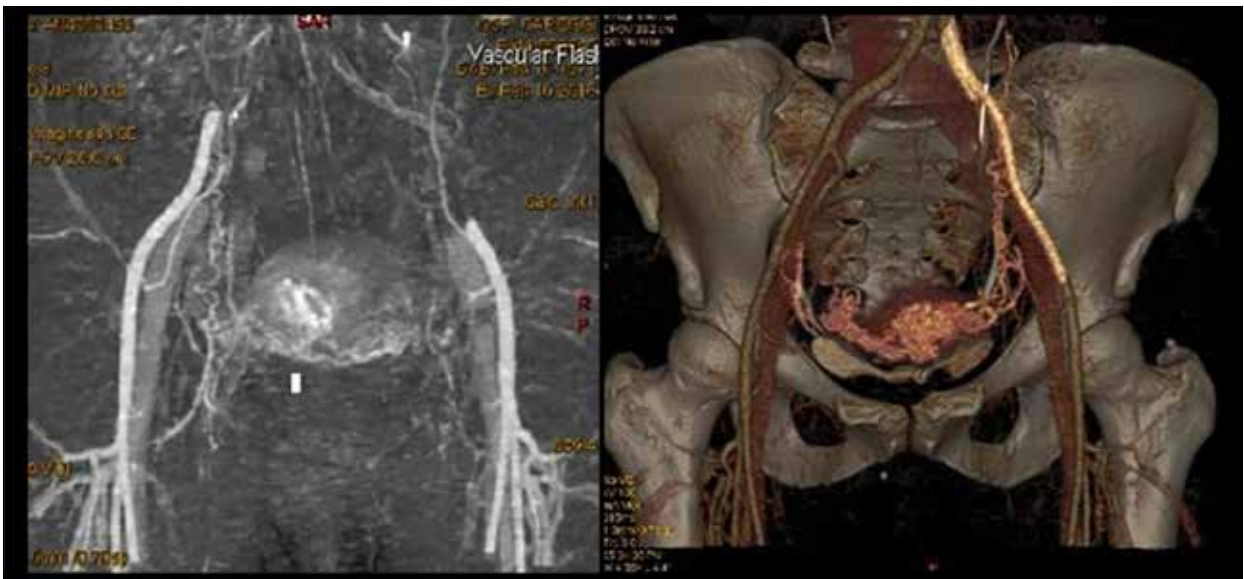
Computed tomography 3D-angiography: hypervascular lesion with arteriovenous shunting and a highly enhanced effect in hypertrophic and coiled vascular channels.
